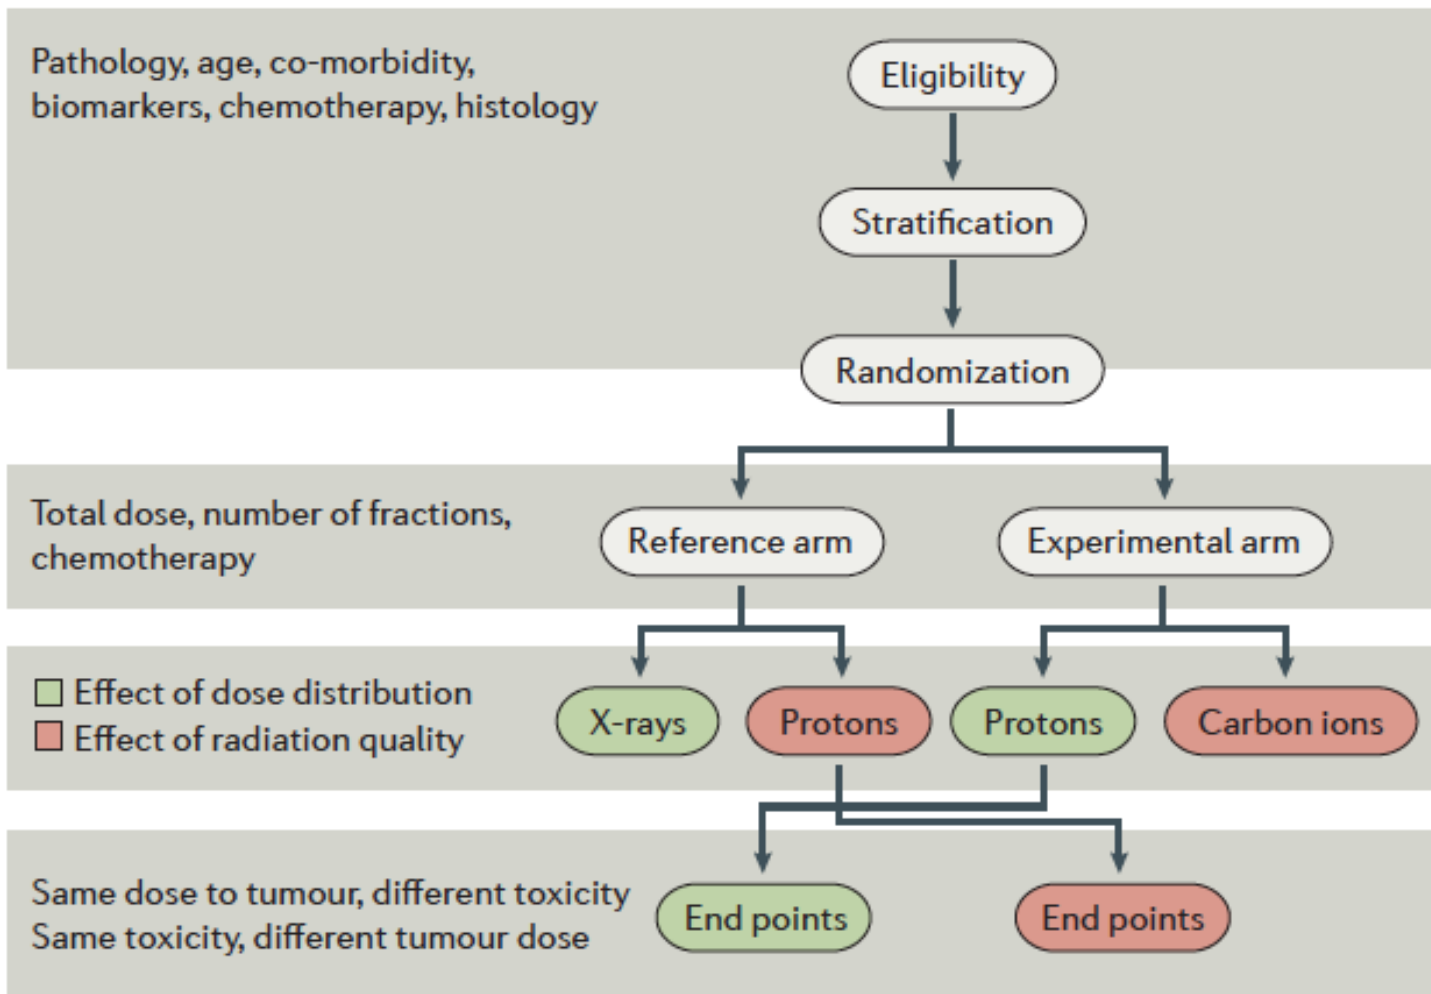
Clinical trial design in charged-particle therapy (CPT). General procedure in CPT trials: patients in the control arm generally receive X-rays, unless the aim of the trial is to compare different charged particles (for example, protons versus carbon ions). Trials of X-rays versus protons or carbon ions compare different physical dose-distributions and the end point can be decreased toxicity (if the same dose to tumour is prescribed), or increased local disease control (if trials prescribe isotoxic doses). Trials comparing protons to carbon ions will have similar physical dose-distribution, and the main end point will be the effect of biological effectiveness.
